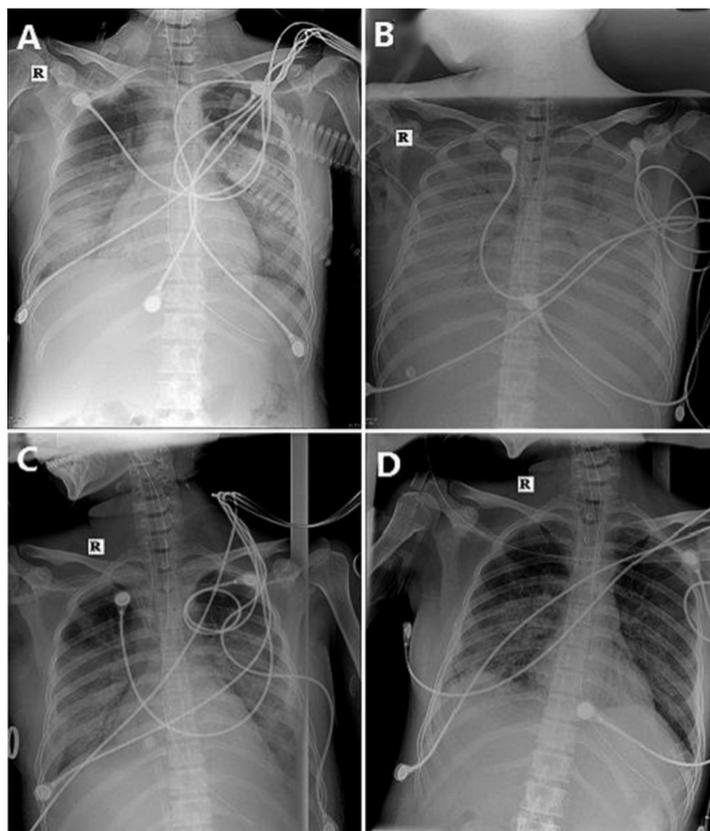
Chest radiograph of reported patient: A) On the 2nd day of admission; B) on the 5th day of admission; C) on the 10th day of admission; D) on the 20th day of admission.
